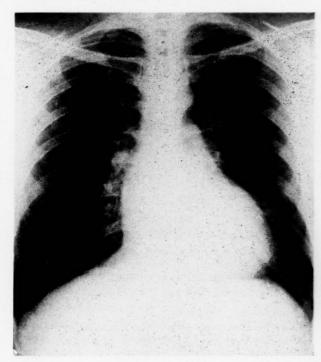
Chest roentgenogram in Case I, typical of left ventricular enlargement seen commonly in aortic stenosis.
